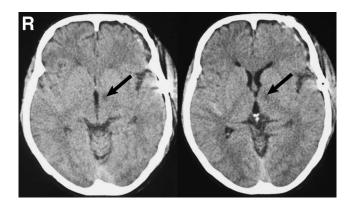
Head computed tomography scans obtained 3 days after the operation showing cerebral infarction at the left genu of the internal capsule (arrows).
